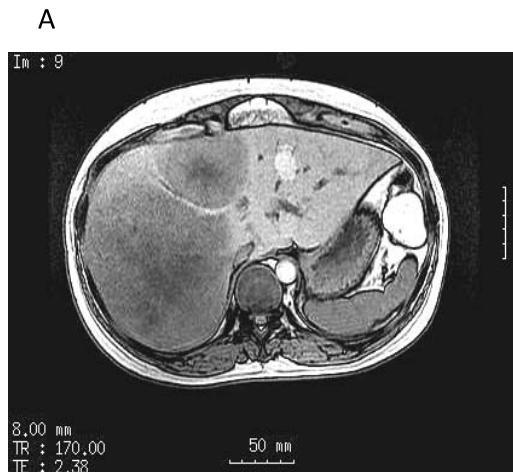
MRI of the liver (A: T1 weighted, B: T2 weighted)
